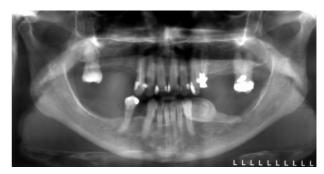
Panoramic radiograph showing a large radiopacity superimposed over the left mandibular cuspid and molar area
